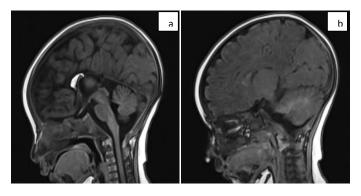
Sagittal T1-weighted MRI shows a pericallosal lipoma, tubulonodular type, appearing as thick hyper-intense band and agenesis of the corpus callosum (a) and a fat-isointense nasal polyp (b).
